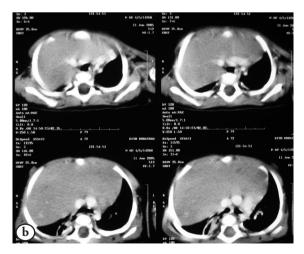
Preoperative computed tomography of chest showing a) mass-filled thoracic cavities, and b) bilateral lung collapse.
